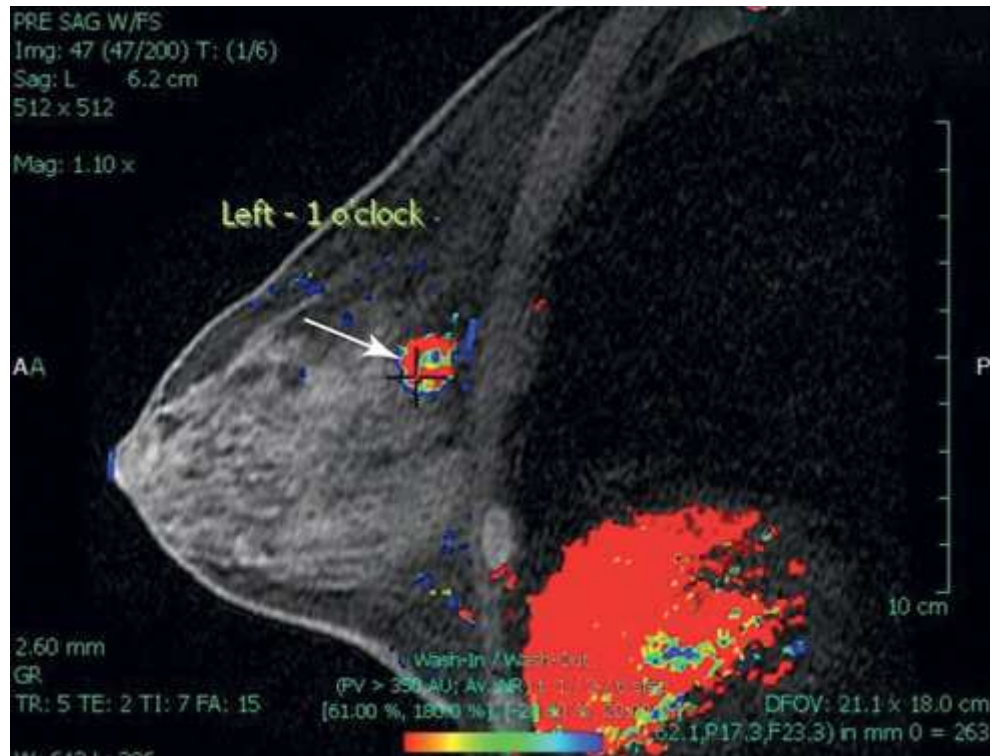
MRI of the breast is postprocessed and showing contrast wash in and wash out. The patient is a 68-year-old woman with an enhancing mass in the left breast at the 1 o'clock position (*arrow*).
